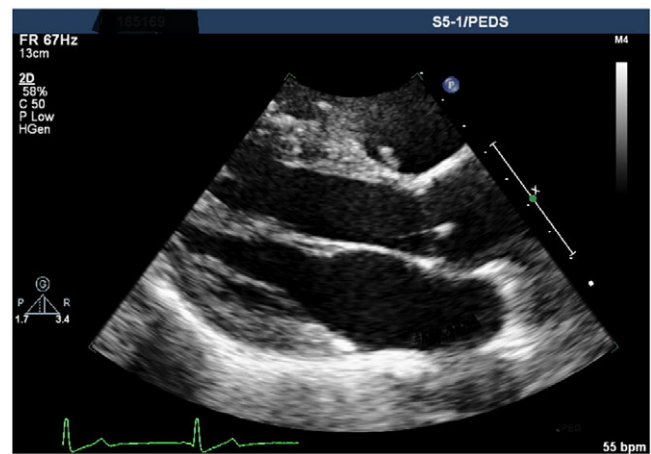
Aortic valve strand in parasternal long-axis view.
